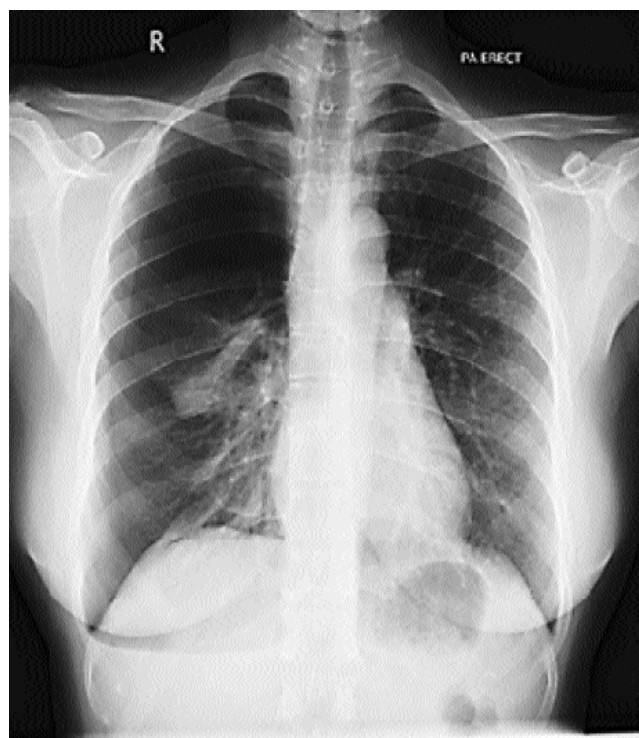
Chest X-ray showing pneumothorax on right side.
